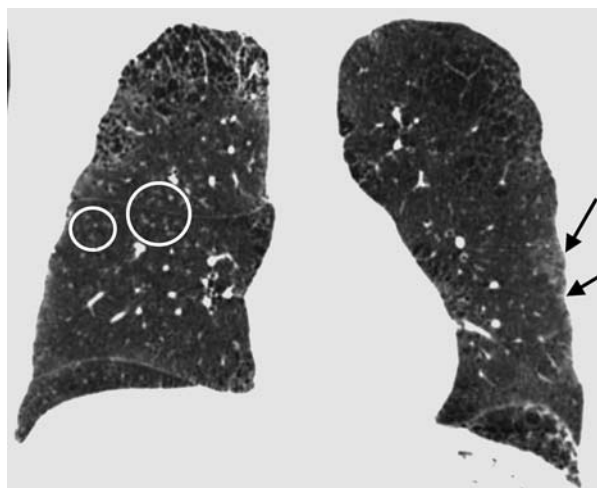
Examples of CN on CT. Coronal CT image of a GOLD 1 subject with moderately extensive visual extent of emphysema. However, the quantitative emphysema score was only 5.1%. The emphysema may have been masked on quantitative assessment by the presence of centrilobular nodules (circled) and patchy ground-glass abnormality (arrows).
